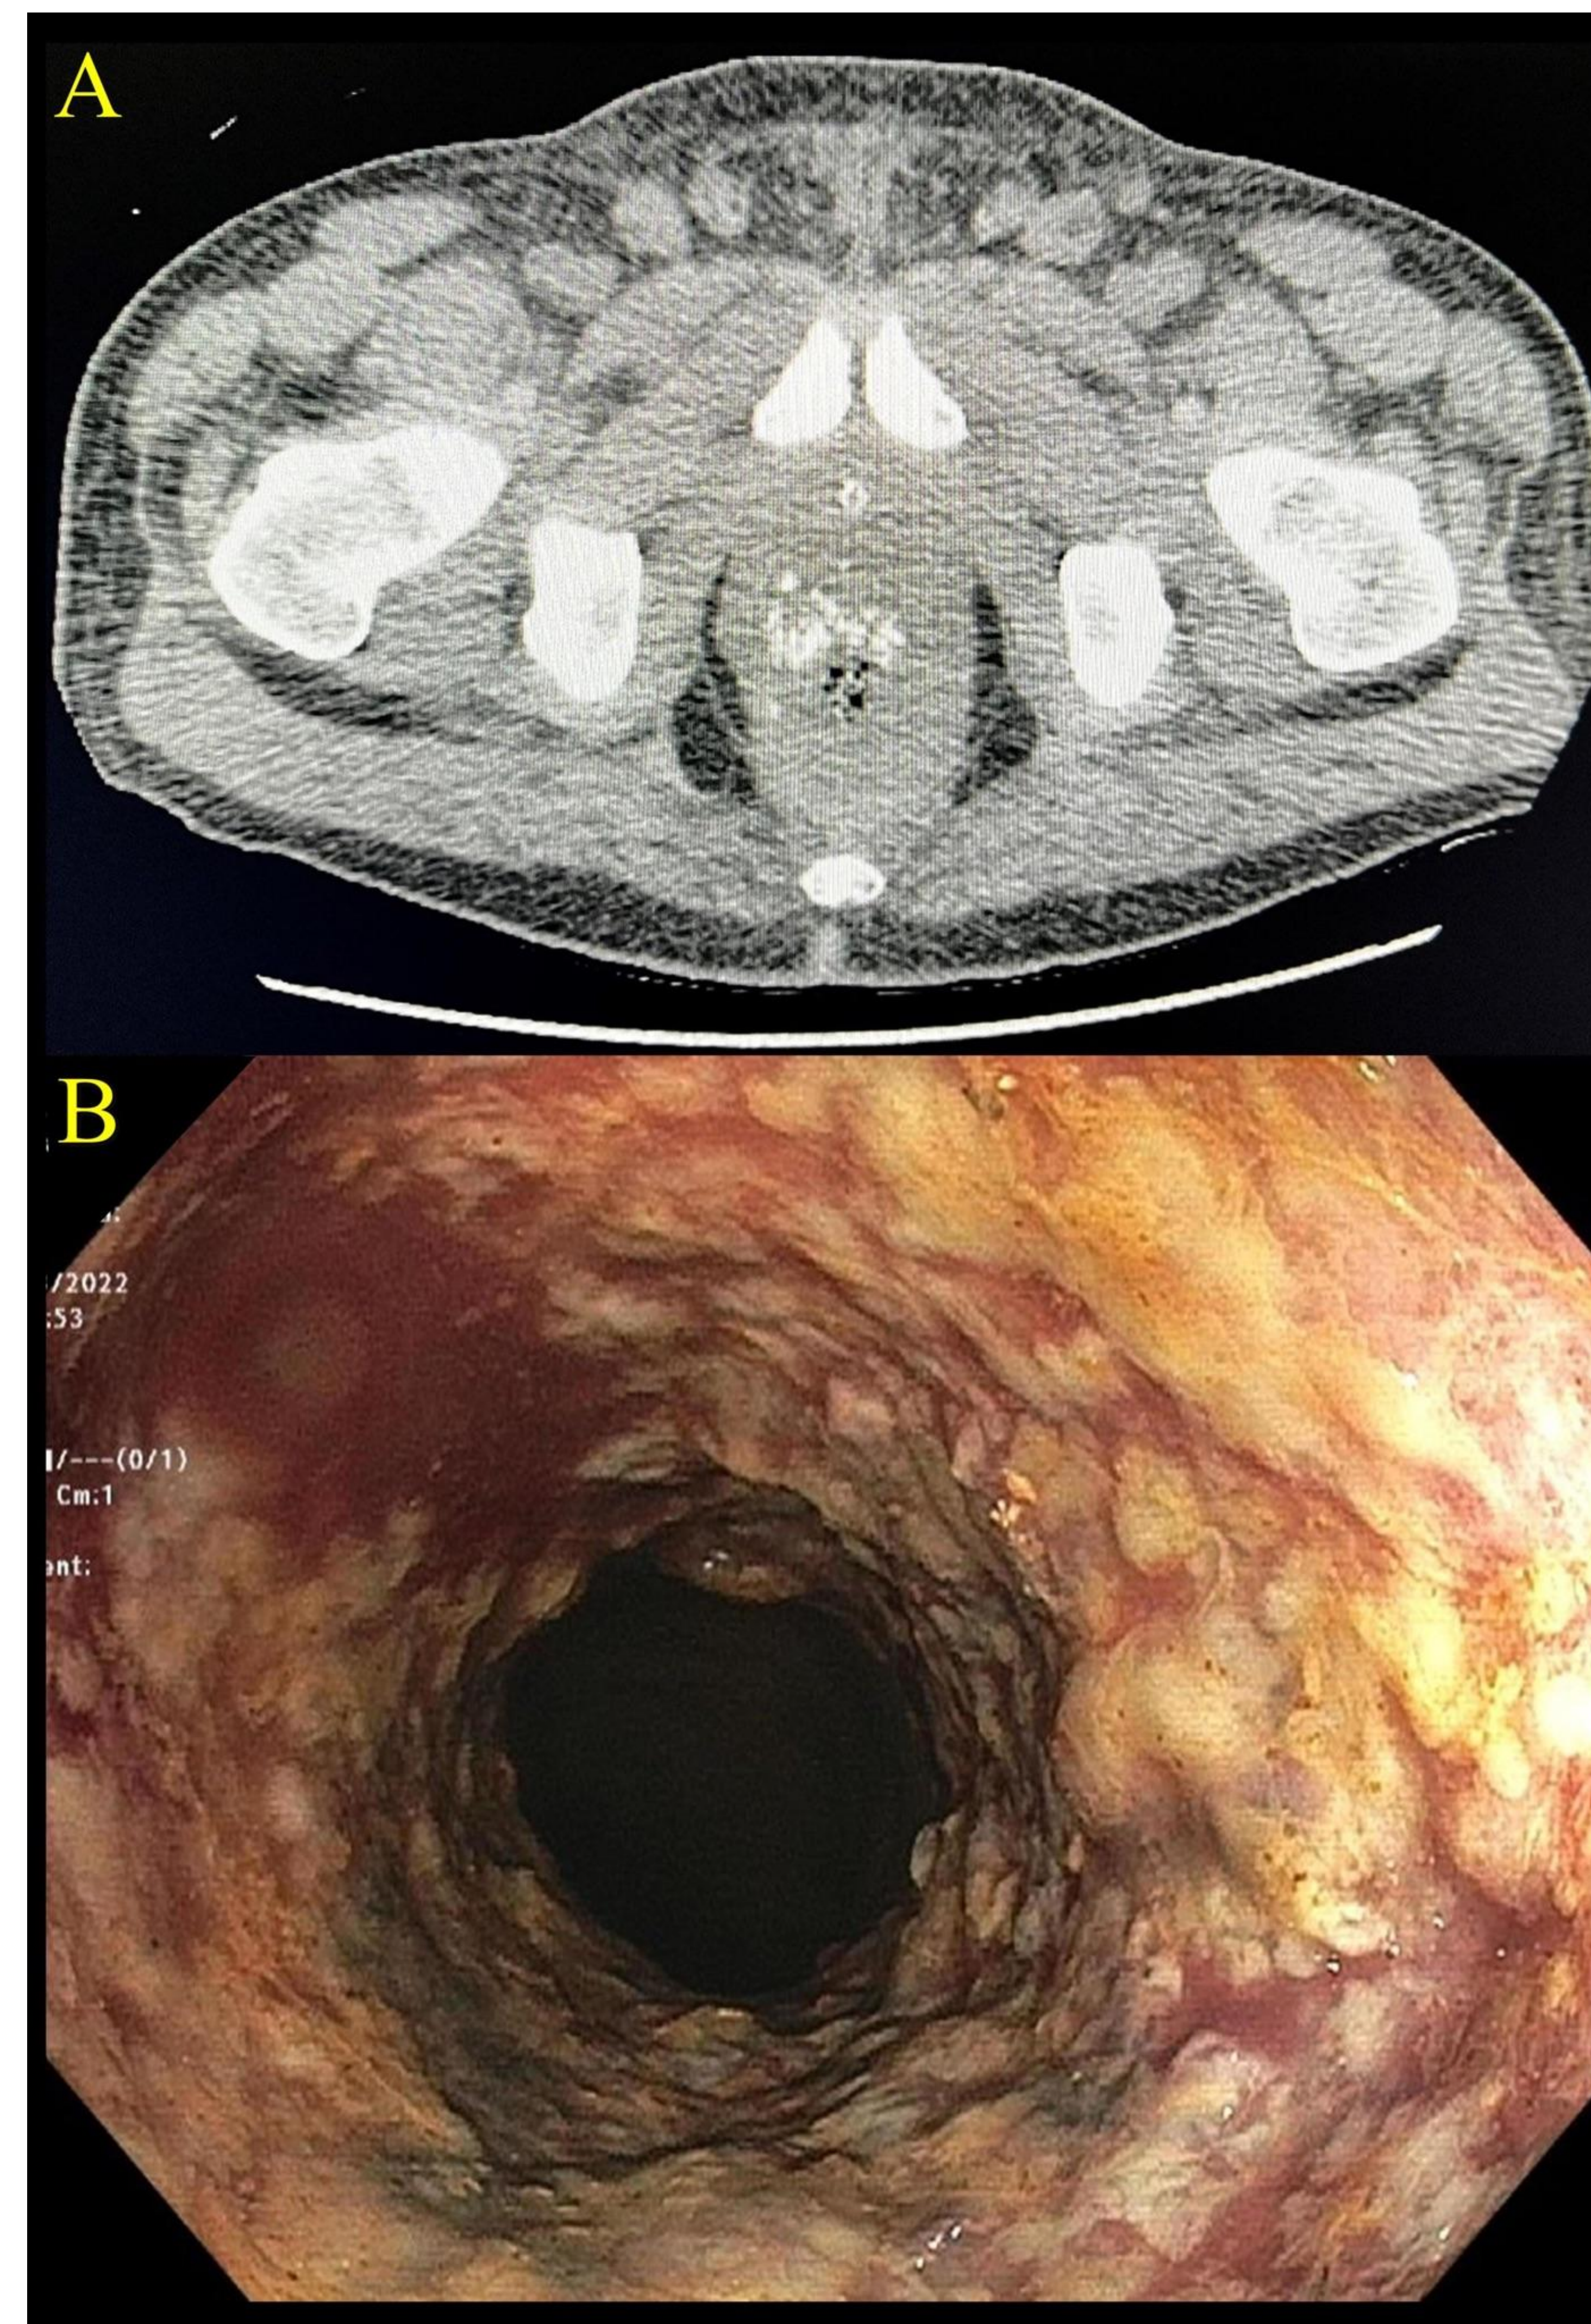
CT of the pelvis with IV contrast showing concentric submucosal thickening of the distal sigmoid/rectum with calcifications. Figure B: Colonoscopy showing severe circumferential inflammation, narrowing, and ulceration of the sigmoid colon.
